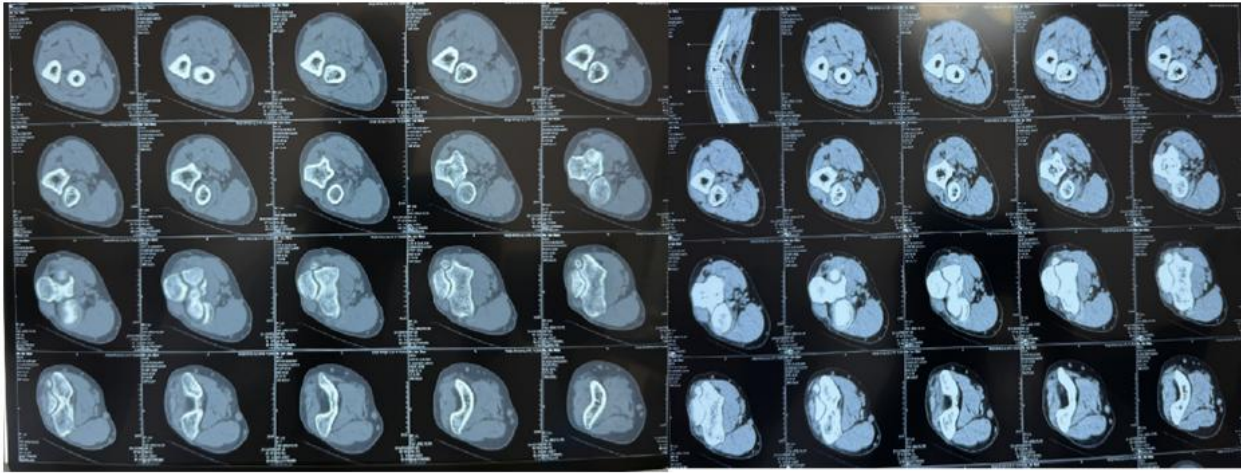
CT of the patient 's right elbow joint
